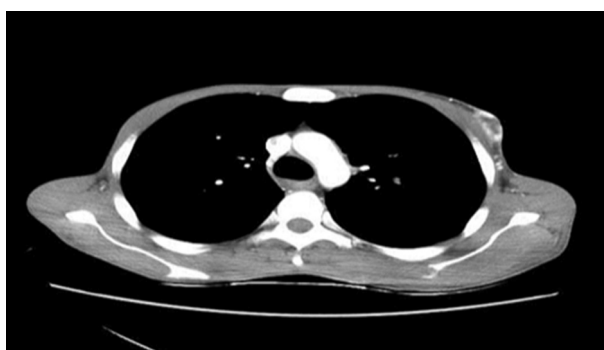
A contrast-enhanced computed tomography scan of the chest, demonstrating left hemithorax lesion
